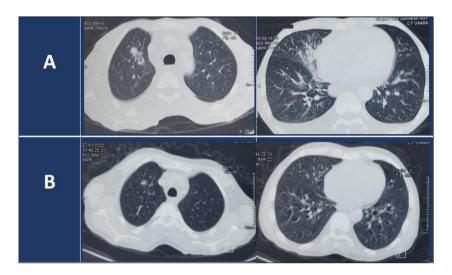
A patient's thoracic CT scan on admission. B patient's thoracic CT scan four months after treatment
